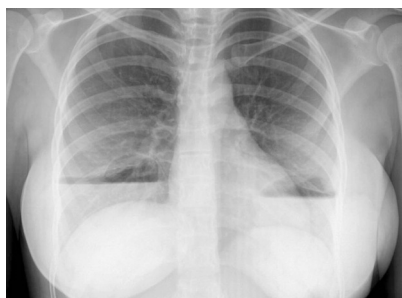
Chest X-ray showing bilateral breast implants with hydro-aerial level s.
